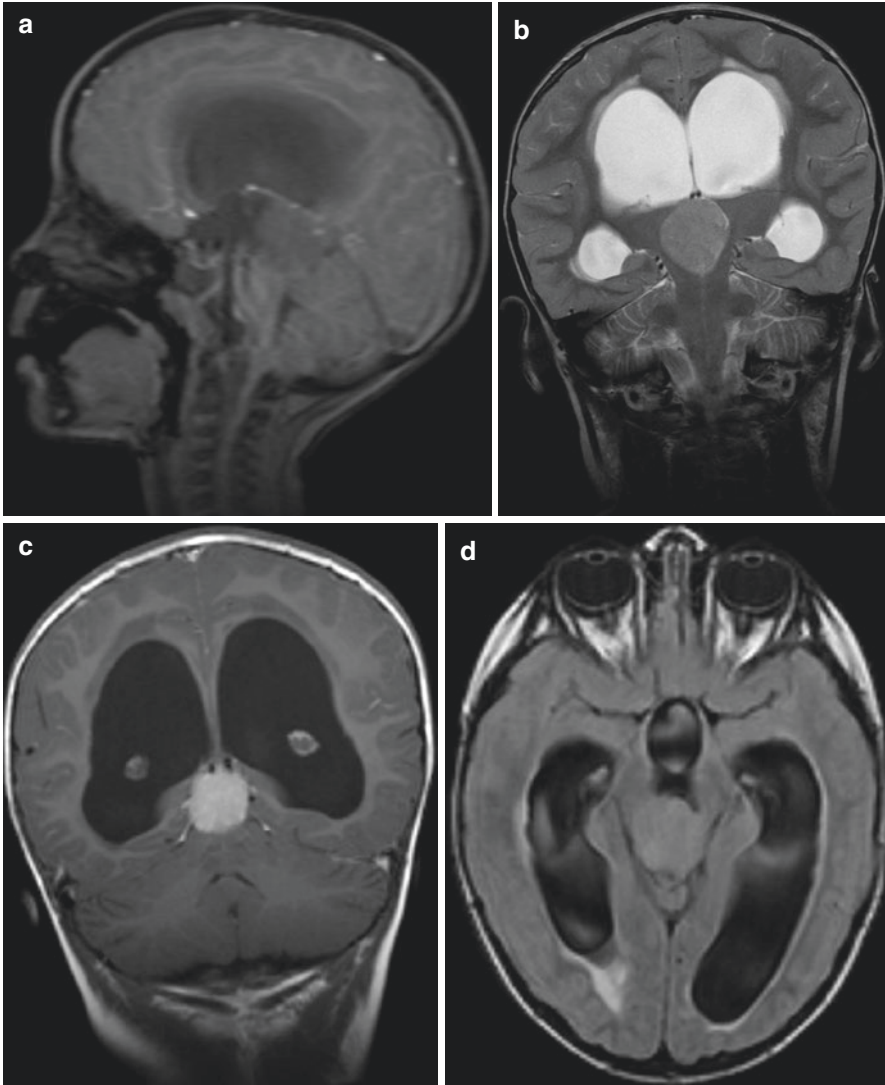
Pineoblastoma in TIWI (a), T2WI (b), T1WI with contrast (c), and FLAIR (d) MRI sequences
